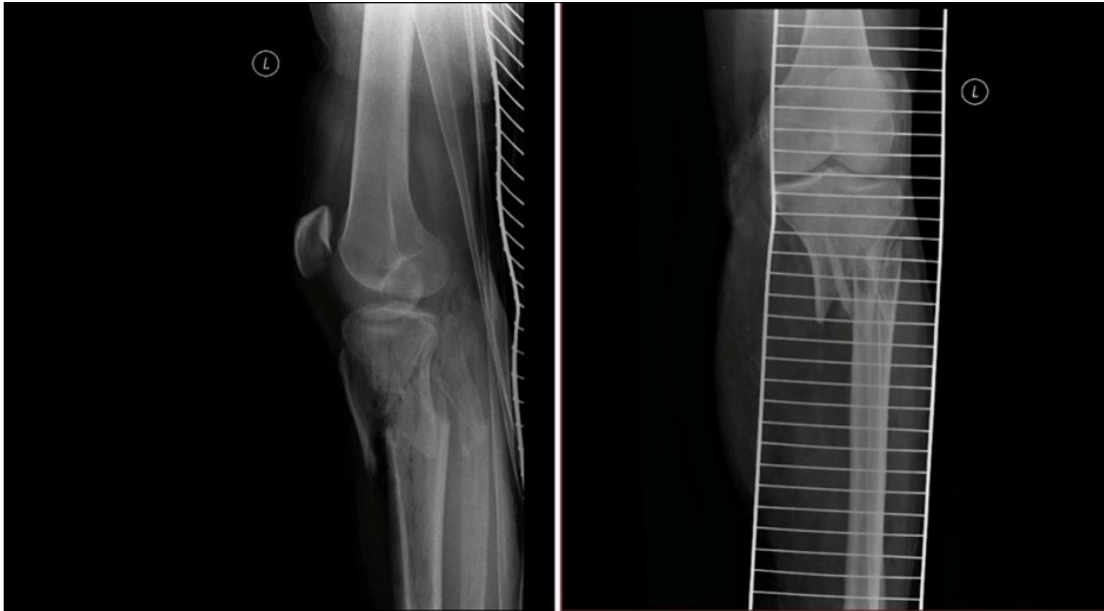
a) 9.10.2015 X-ray
